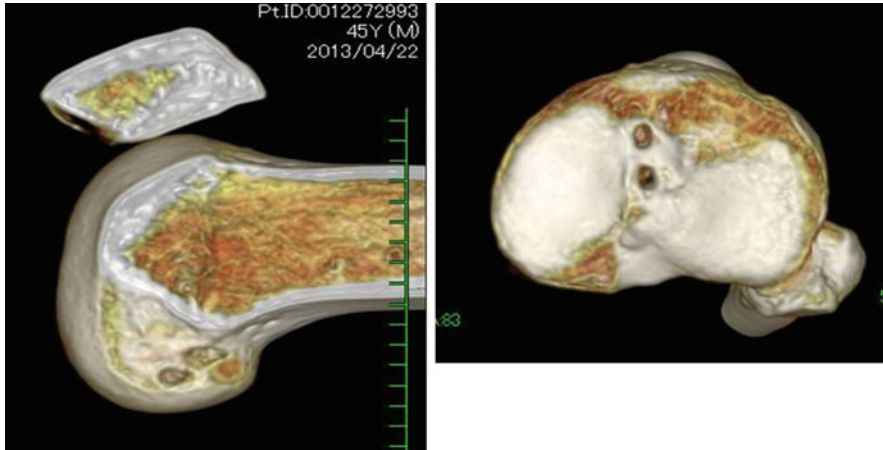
After surgery, the grafted position was evaluated by 3D CT, as shown
